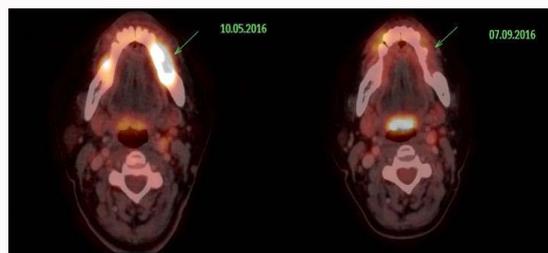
PET-CT scan done 4 months after treatment showing complete regression of the lesion.
